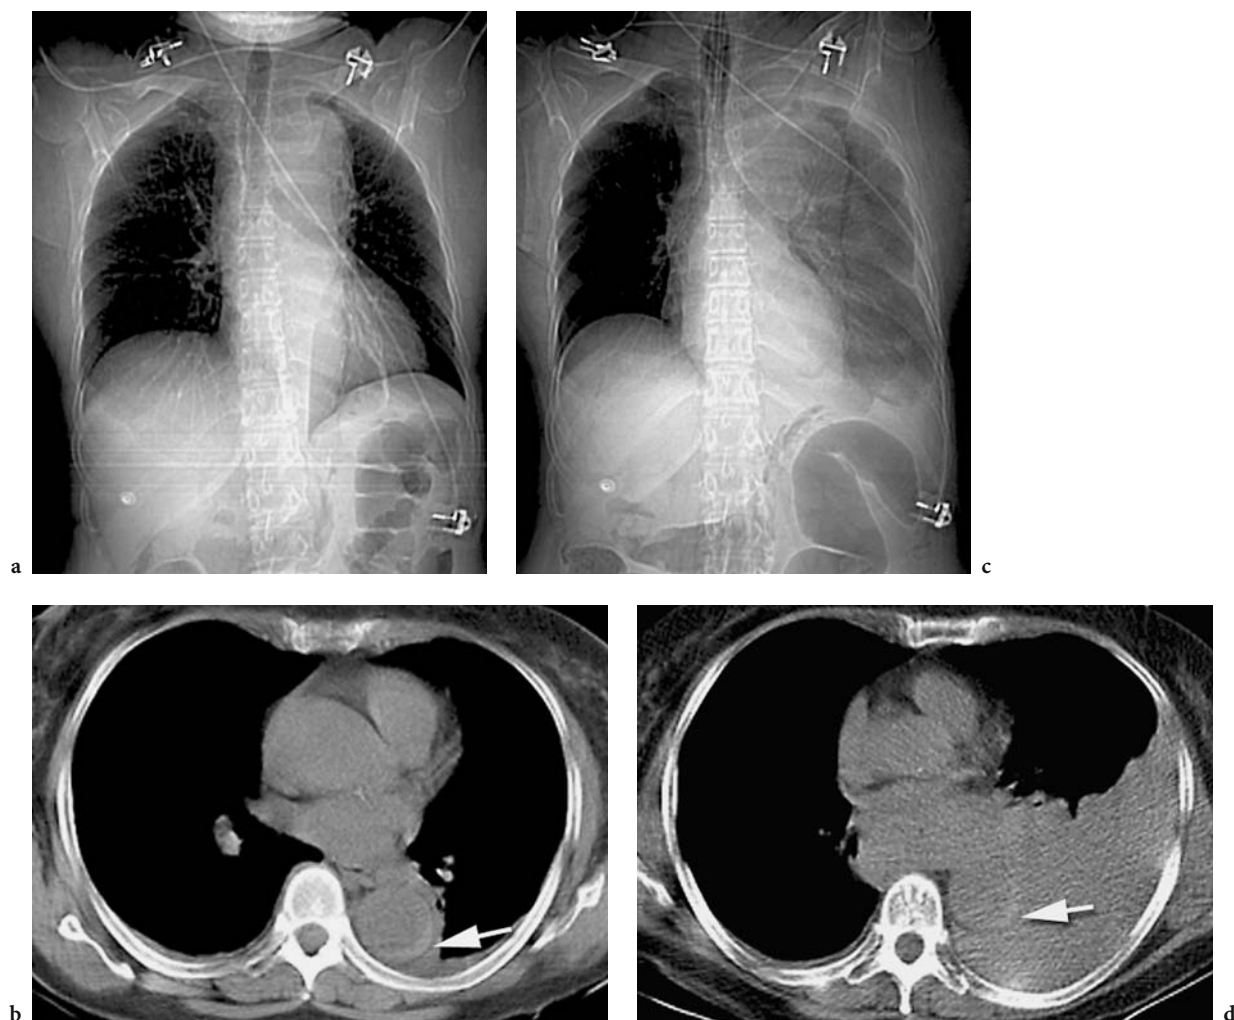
a Frontal projectional radiograph of the chest demonstrates a widened aortic arch in a patient with acute chest pain. b Unenhanced transverse CT section obtained in anticipation of performing a CT angiogram demonstrates a high-attenuation crescent within the posterior wall of the descending aorta (*arrow*). A small left pleural effusion is present. This high-attenuation crescent is pathognomonic for an intramural hematoma. Prior to performing the ensuing CT angiogram, the patient became acutely hemodynamically unstable on the CT table necessitating cardiopulmonary resuscitation. c Forty-five minutes after the initial acquisition, a, b the patient was stabilized hemodynamically. A repeat frontal projectional radiograph demonstrates that the left hemothorax is now filled with fluid. d Transverse CT section at this time demonstrates a large left pleural effusion (*arrow*), which was subsequently demonstrated to represent blood due to acute rupture of the aorta at the site of the intramural hematoma. The high-attenuation crescent within the aortic wall, which is now displaced anteriorly, compared with the earlier cross section, is still visible
